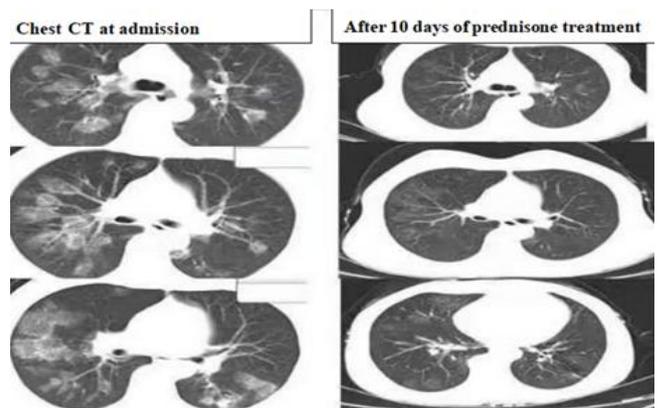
Chest CT at admission (first colon), and after 10 days of prednisolone treatment (second colon)
